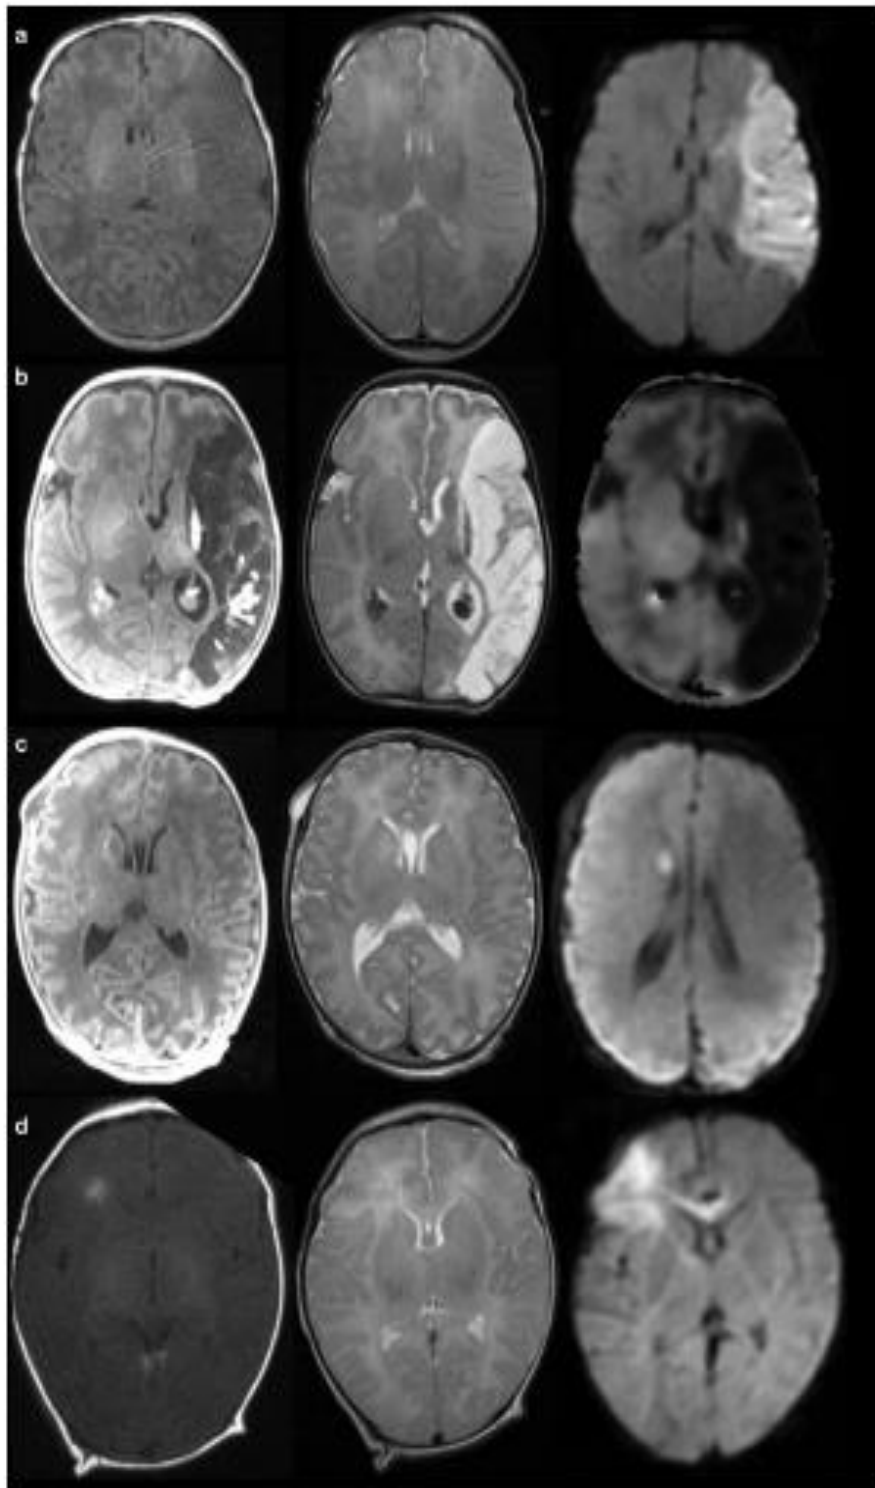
Magnetic resonance imaging in the axial plane of Perinatal Arterial Ischaemic Stroke (PAIS) in the middle cerebral artery territories. Left column T1-weighted, middle column T2-weighted, and right column diffusion weighted sequences. Row a – PAIS affecting the territory of the main branch of the left middle cerebral artery. Images show loss of grey white matter differentiation on T1w and T2w sequences with restricted diffusion on DWI. Row b – imaging performed outside the neonatal period demonstrates maturation of the PAIS from row a. Row c – imaging demonstrates a right head of caudate nucleus acute infarct with restricted diffusion
